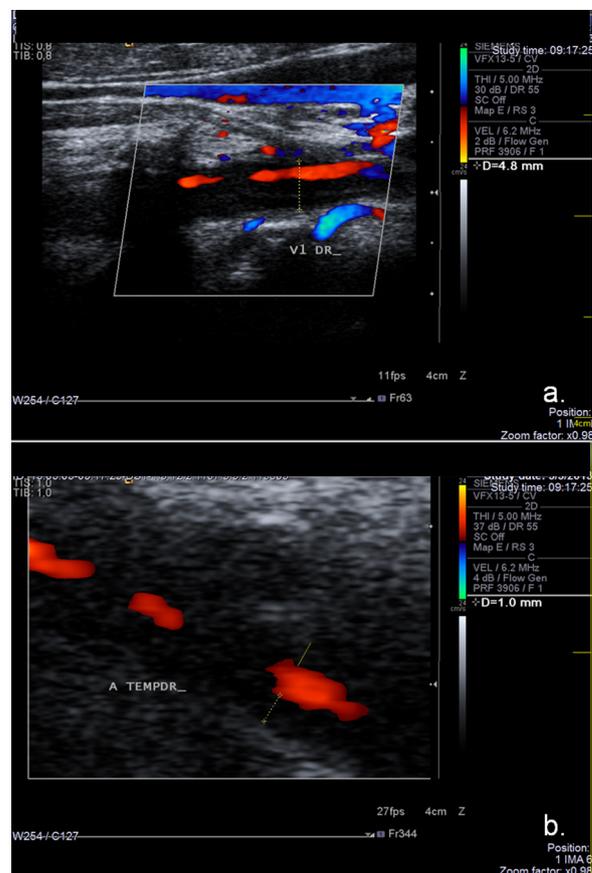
Case 3. Temporal arteritis in a 72-year-old woman. Colour duplex ultrasound examination of the right vertebral (a) and temporal (b) arteries (longitudinal sections) showing a pronounced eccentric hypoechoic mural thickening of the vertebral artery (a) and concentric hypoechoic mural thickening of the temporal artery (b).
